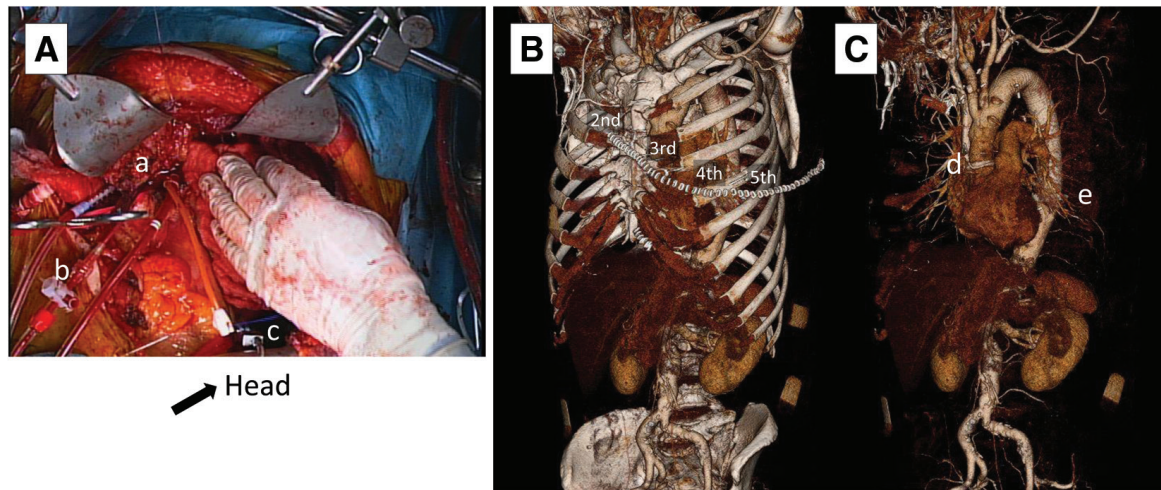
Single-stage aortic replacement from the ascending aorta to the distal descending thoracic aorta through an extended thoracotomy in a patient with a history of ascending to aortic arch replacement. (A) Operative view. (a) A clamp on the ascending aortic graft. (b) A cardioplegic needle. (c) A clamp on the descending thoracic aorta. (B and C) Postoperative 3-dimensional computed tomography showing the incision (B) and the reconstructed aorta (C). (d) Proximal anastomotic site. (e) Distal anastomotic site.
